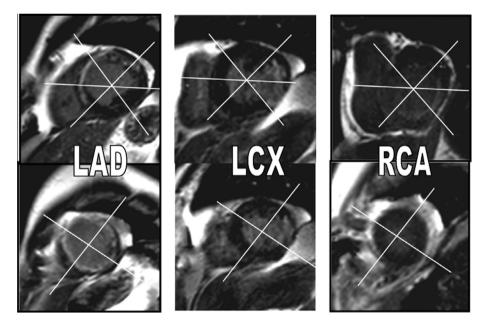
Post Gd DTPA IR sequence in short axis planes at the mid-cavitary and apical levels in 3 different patients. Note the apical four segments can be affected in LAD territory. The inferior segment was not totally specific to RCA territory.
